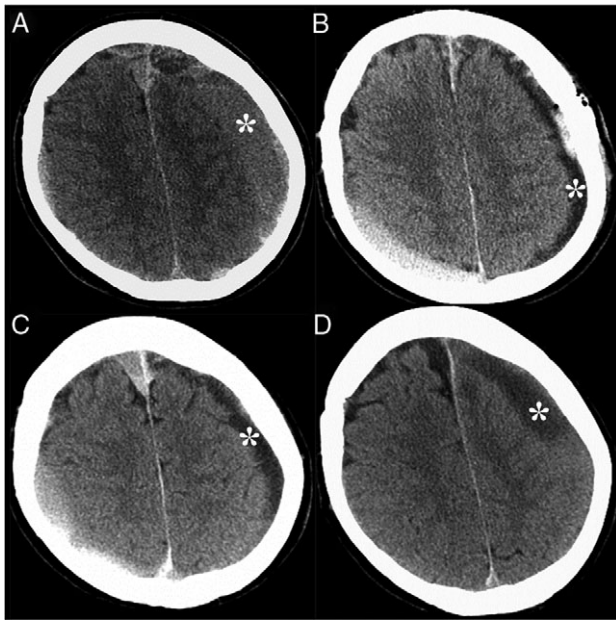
CT of the head without contrast demonstrated CSDH, denoted by the asterisks, at the initial presentation (A), after the procedure (B), 7 days later (C) and 4 weeks later, when the CSDH has enlarged (D). Acute subdural hematoma was also noted in the right posterior frontoparietal region.
